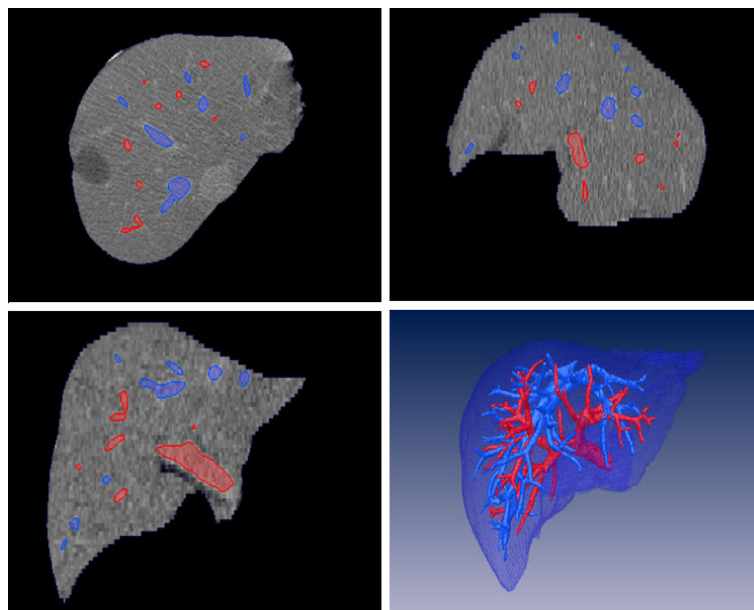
The result after applying the proposed processing chain to a CT dataset of the liver. Top left, right and bottom left: Transversal, Sagittal and Coronal slices of the segmented organ with portal vein overlayed in red and liver vein in blue. Bottom right: 3D visualization of the result. Image taken from [DOOL11].
